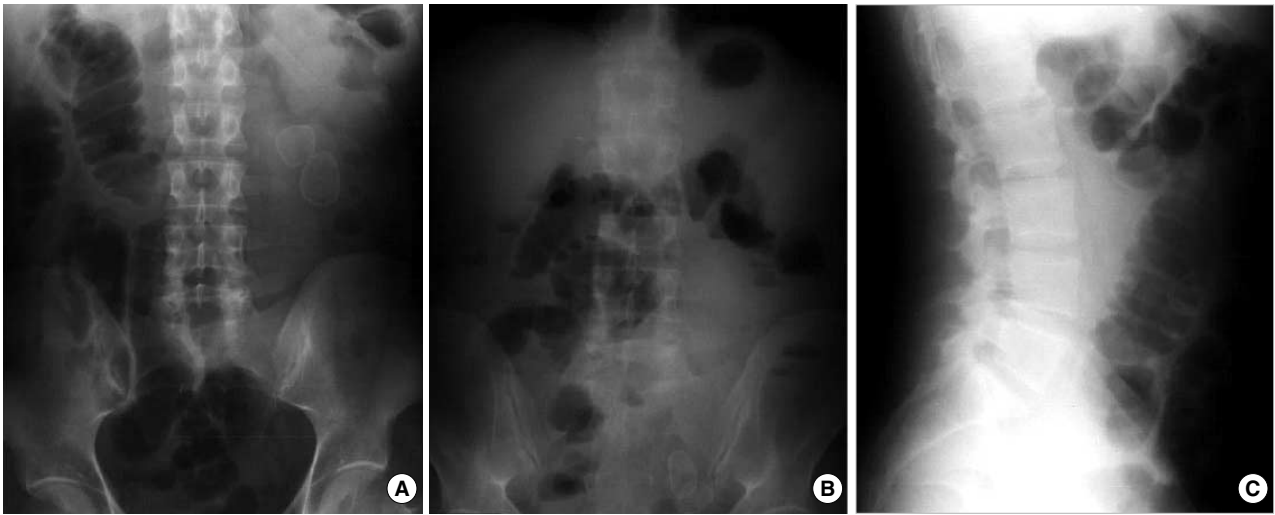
Two calcified opacities were detected in the left iliac fossa at the supine radiograph (RX), (A) which changed location at the erect RX. (B) At profile plain RX of the abdomen these two intraluminal abnormalities appeared in the dilated small bowel of terminal ileum, (C) compatible with gallstones.
